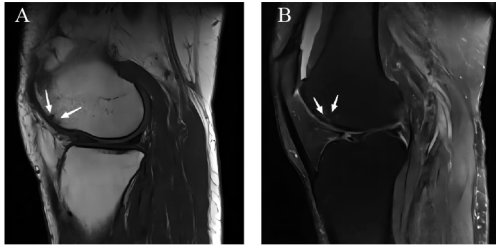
Magnetic resonance imaging (MRI) of knee OA in a 65-year-old female. (A) Sagittal T1-weighted images shows minor subchondral-bone collapse in the distal femur, with subchondral-bone microfractures presenting as low signal (white arrow). (B) Sagittal T2-weighted fat suppression image shows the same lesion in the distal femur (white arrow).
